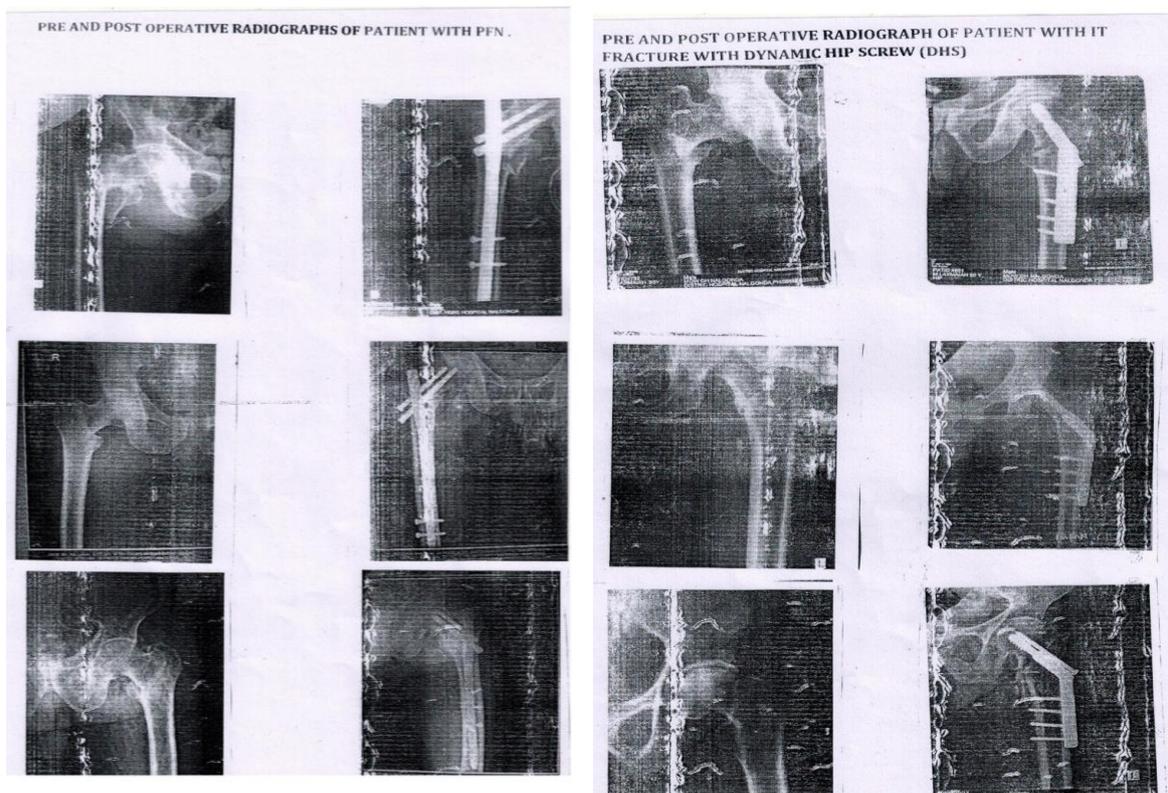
Pre and post operative radiographs comparative between PFN and DHS
